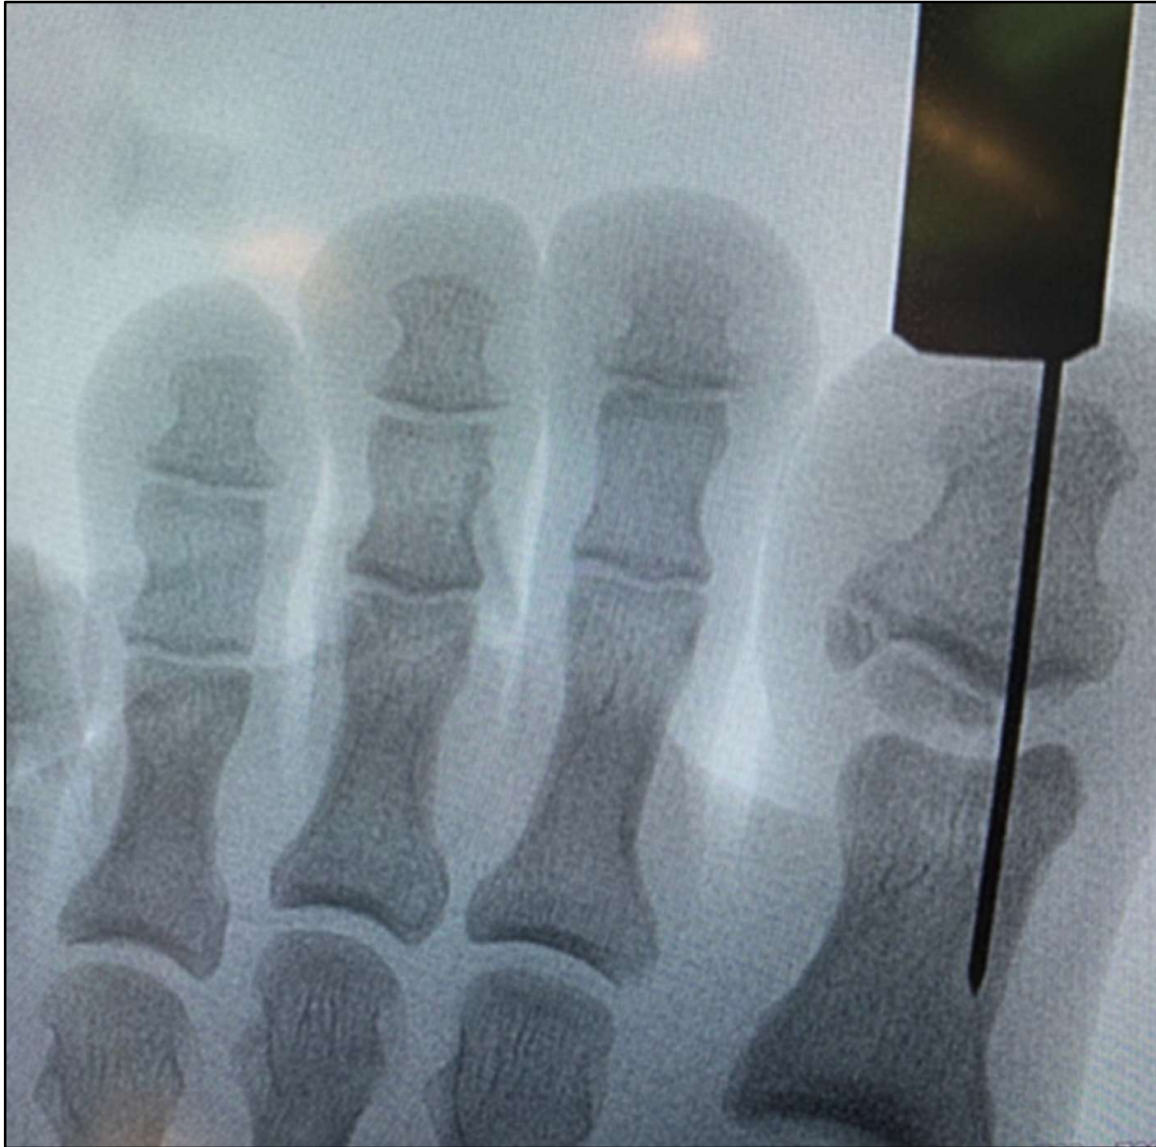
Intraoperative X-ray of the left foot shows bony fragments entrapped in the interphalangeal joint space, with K-wire in place percutaneously inserted to maintain the reduction.
